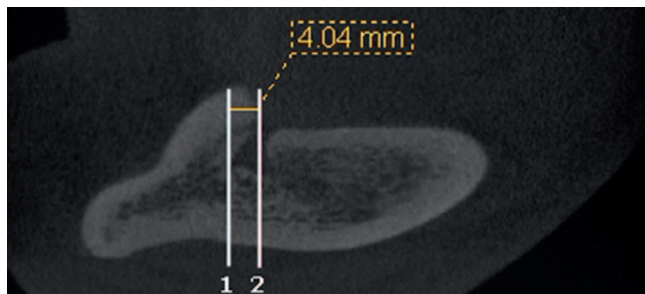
Cone-beam computerized tomography image of patient shows the anterior loop with 4.04 mm. Anterior loop length is the distance between the anterior borders of the inferior alveolar canal curve (1) and the mental foramen (2).
